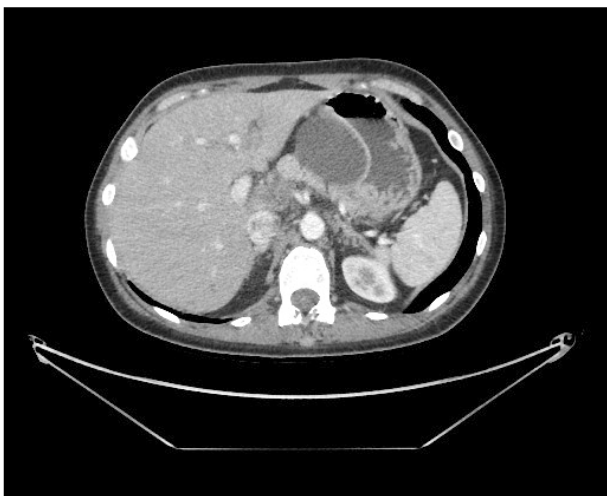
Axial CT image showing a large 4.8×6.3×5.1 cm cystic lesion at the body of the pancreas.
